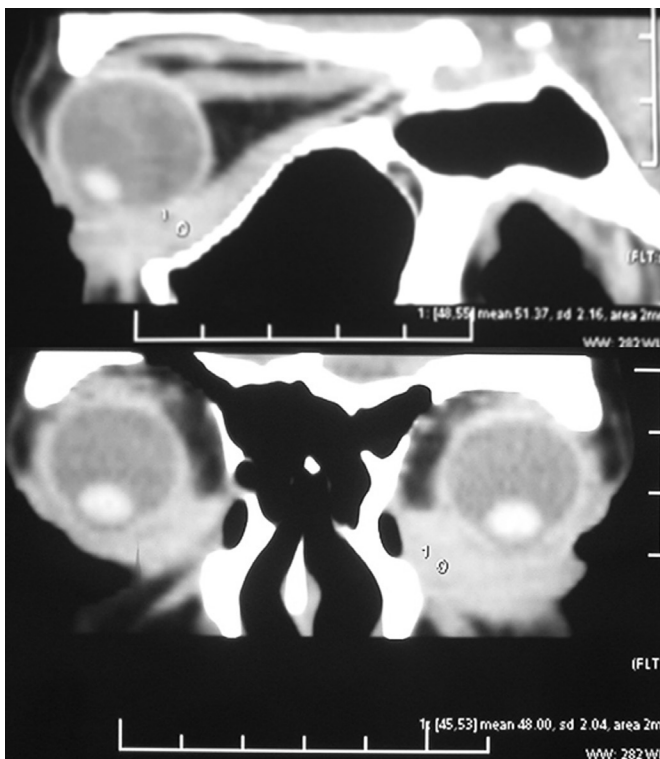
Orbital CT scan showing a circumscribed but not well-defined mass in subcutaneous tissue of the inferior eyelid arising from the inferior portion of the left orbit.
